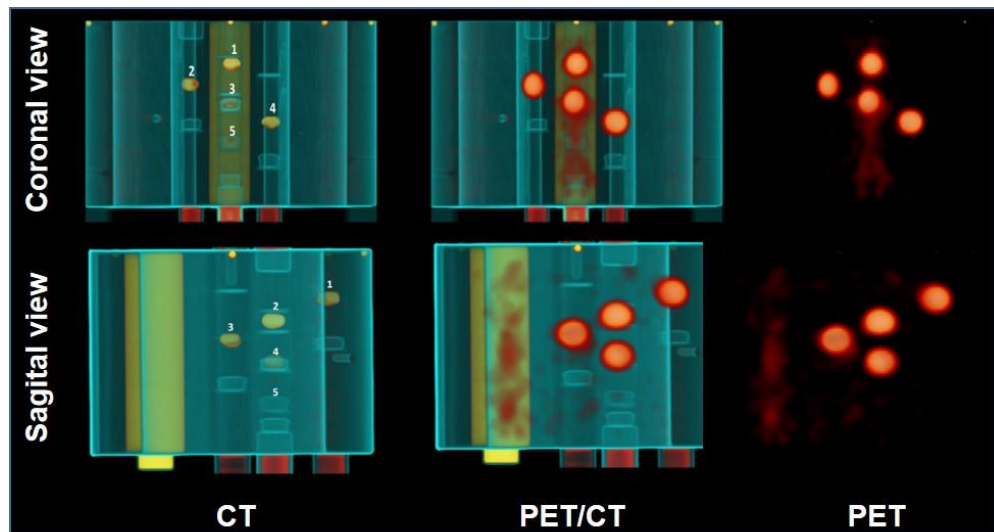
Coronal- and right sagittal view of 3D reconstructions of CT (left), PET/CT (middle), and PET (right) images. The gel positions are labelled on the CT reconstruction. The underlying PET images were reconstructed with a 3D iterative method for better visualization.
